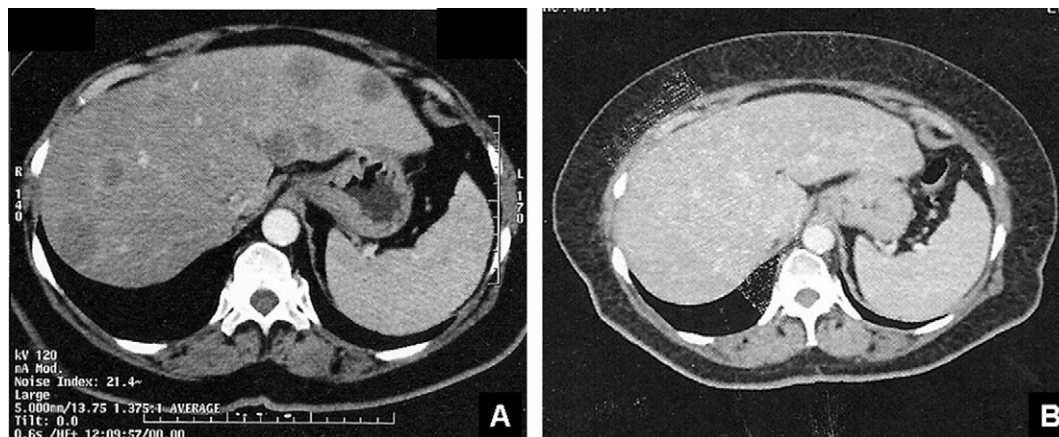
Abdominal CT-scans of a patient with hepatic hemangio-endothelioma before initiation of oral CPM (panel A), and after 2 months of treatment (panel B), showing a complete response.
